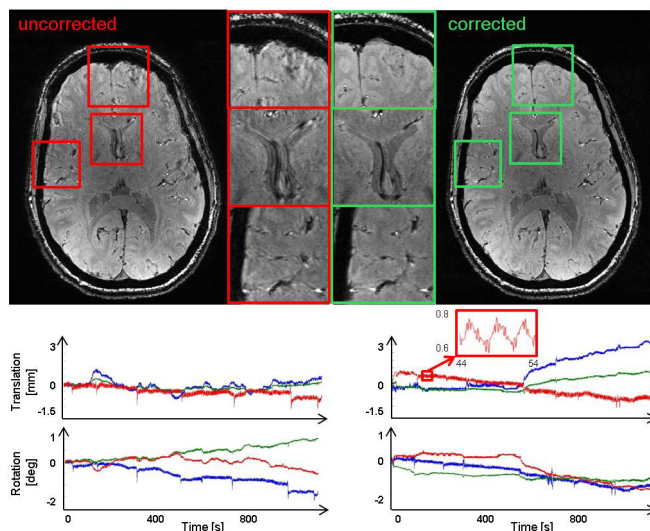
The volunteer was asked not to move during acquisition of the uncorrected (left) and corrected (right) 0.4 mm isotropic 3D FLASH images. The corresponding motion time courses are shown below the MR images.
